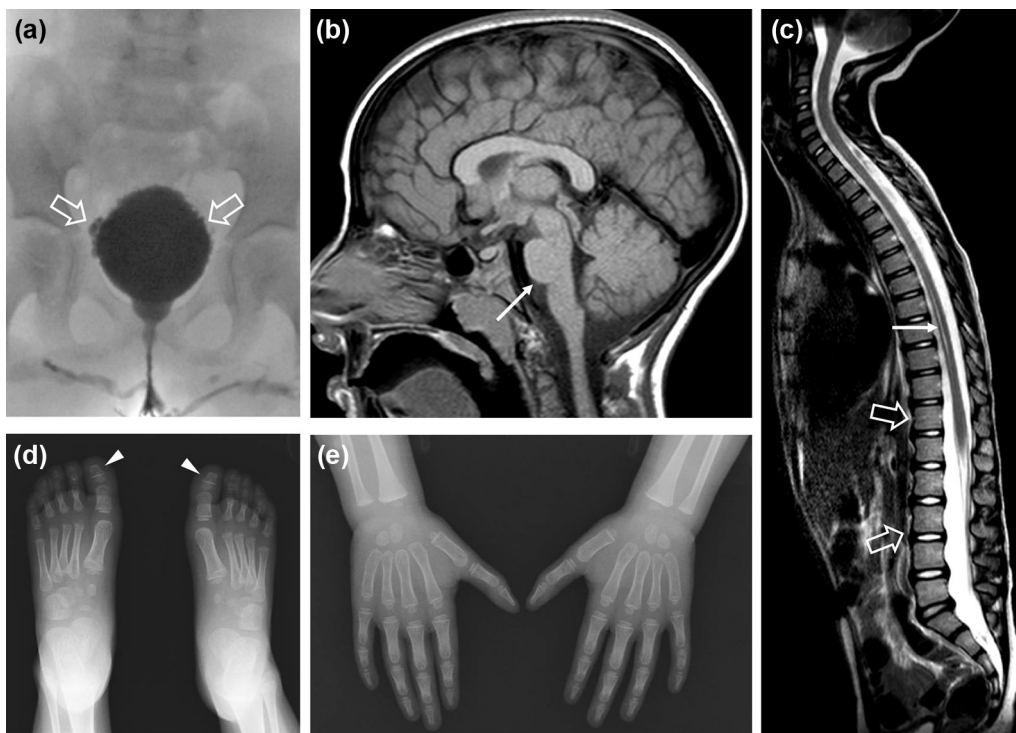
(a) Voiding cystourethrogram, frontal view, reveals irregular bladder wall profiles with pseudo-diverticula (empty arrows), without evidence of vesico-ureteric reflux. (b) Brain MRI, sagittal T1-weighted image, demonstrates mild pontine hypoplasia with reduction of the cranio-caudal diameter of the pons (arrow). (c) Spinal MRI, sagittal T2-weighted image, shows tall and slightly foreshortened vertebral bodies at the lumbar level (empty arrows). There is also minimal, nonsignificant dilatation of the central canal of the dorsal spinal cord (arrow). (d, e) Hand and feet radiograph performed at 2.7 years of age demonstrated slightly delayed bone age. Bone age in this case is 2 years as per Tanner. Note the short squared distal phalanges of the feet (arrowheads).
